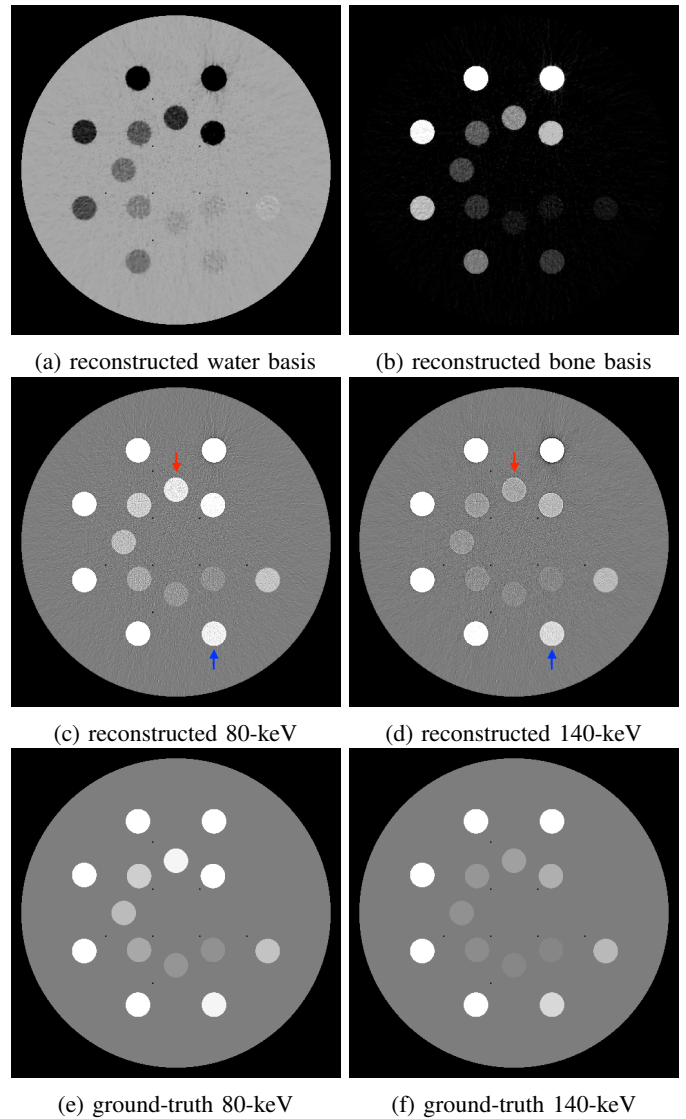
First row: reconstructed (a) water- and (b) bone-basis images with the ASD-NC-POCS algorithm from the data collected with the nanotube X-ray source array. Second row: reconstructed monochromatic images at (c) 80 and (d) 140 keV. Down and up arrows ( $\downarrow$  &  $\uparrow$ ) point to two inserts of different materials (15-mg/ml iodine and 100-mg/ml calcium, respectively) that are difficult to separate in a single-energy CT, such as in the 80-keV monochromatic image, but are better differentiated in dual-energy CT with the help of 140-keV monochromatic image. Such two inserts at focus are to mimic the behavior of water and explosive ANFO in the scan of single- and dual-energy CT. Third row: ground-truth monochromatic images at (e) 80 and (f) 140 keV.
